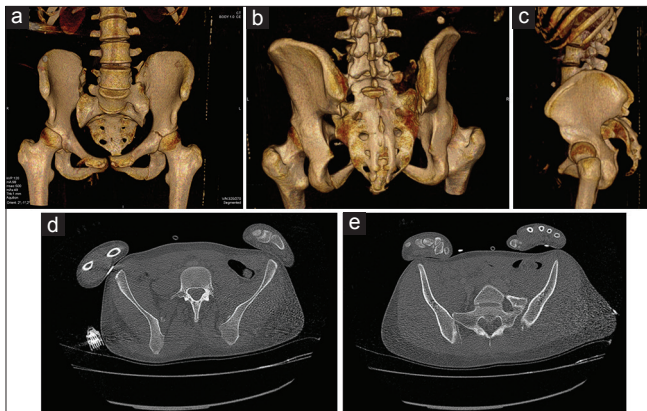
(a-e) Three-dimensional CT revealing total bilateral sacroiliac joint dislocation and fractures of the pubic ramus and acetabulum
